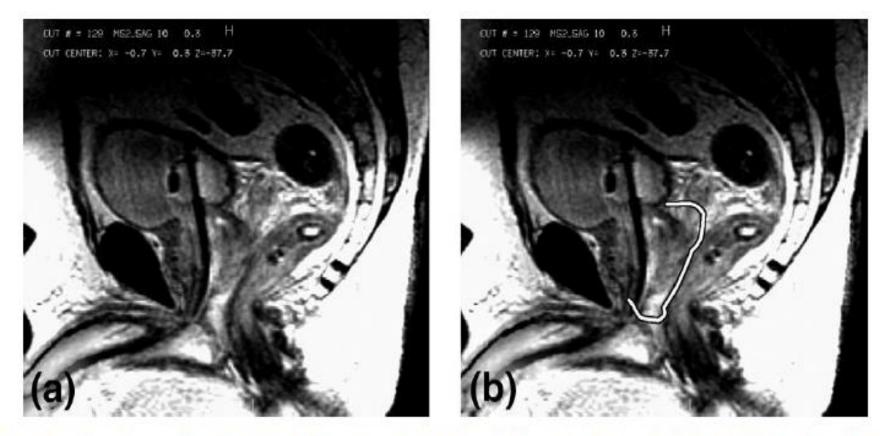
Contact of prostate and rectum. (a) Minimal contact by magnetic resonance imaging. (b) White line demonstrates a typical computed tomography prostate contour drawn in reference to rectum.
